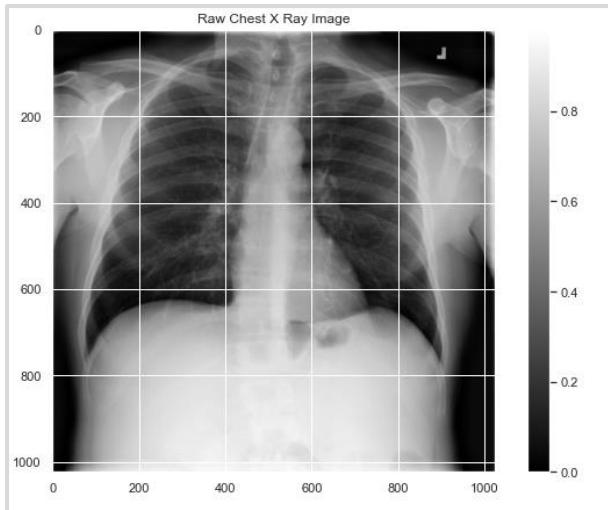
3 A chest x-ray image
